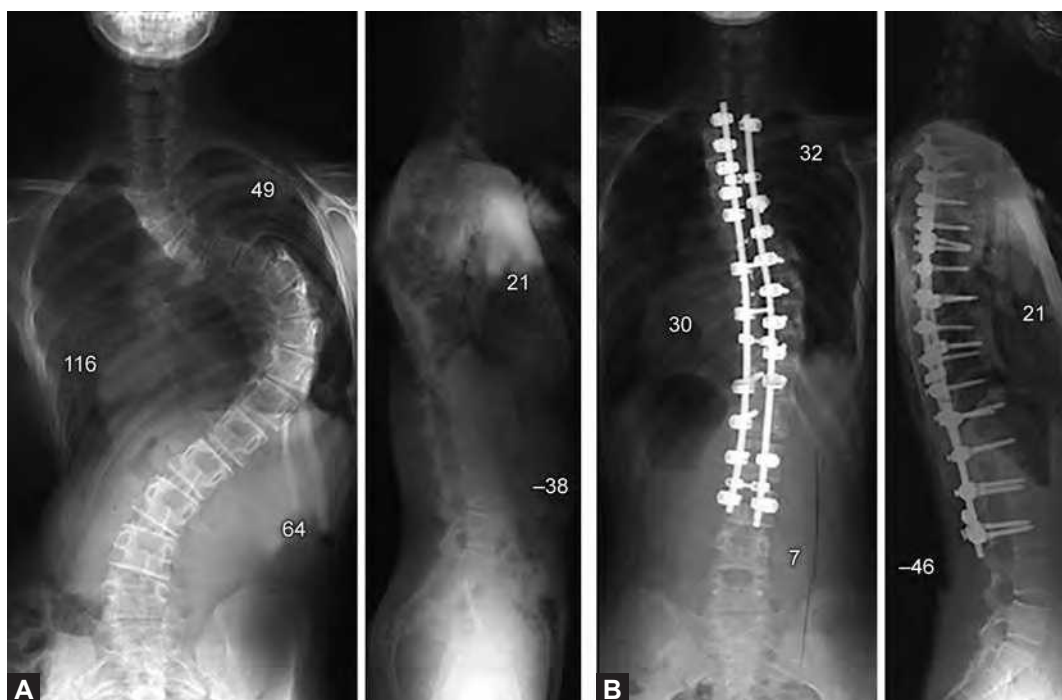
Asymmetrical chevron-shaped osteotomy. Multiple asymmetrical chevron-type osteotomies were planned on the periapical segments from T7 to T12 for correction of severe scoliosis.
